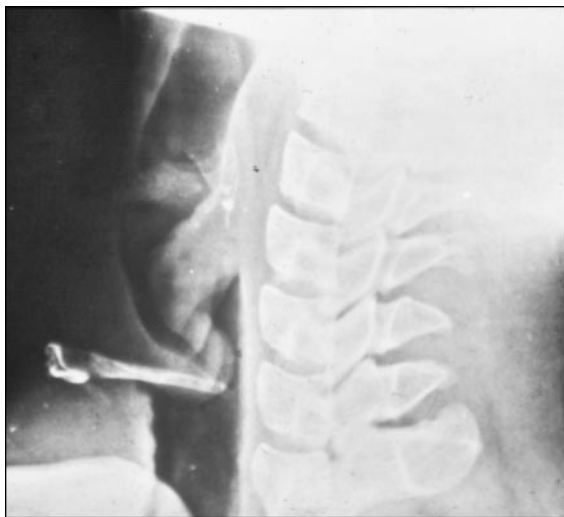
Lateral neck radiograph demonstrating the classic "thumb sign" seen in epiglottitis.
